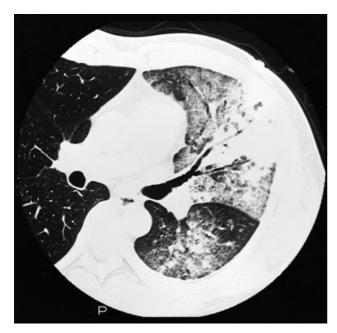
High-resolution computed tomography of the chest shows a high-density area in the entire lingular segment and lower lobe with air bronchograms.
